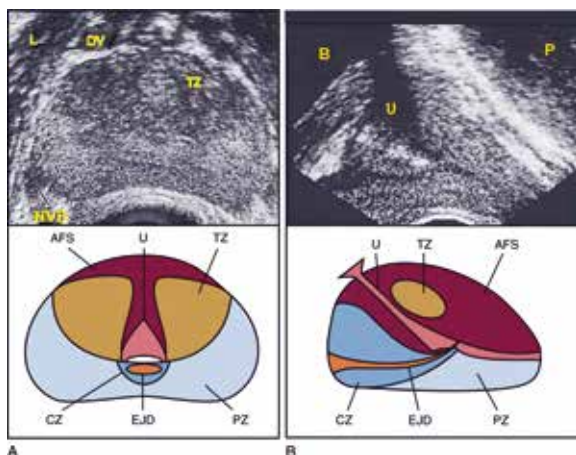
Normal prostate ultrasound images with zonal anatomy
